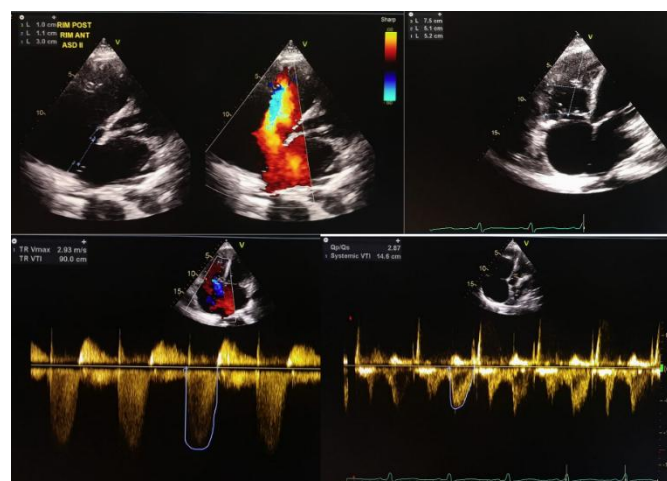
Echocardiography (ASD II L To R shunt, LV Concentric Remodeling with good LV Contractility EF 65 % (Simpson 62 %), Grade I Diastolic Dysfunction, TR dan MR Moderate dan PR Mild, Intermediate Probability of PH)
